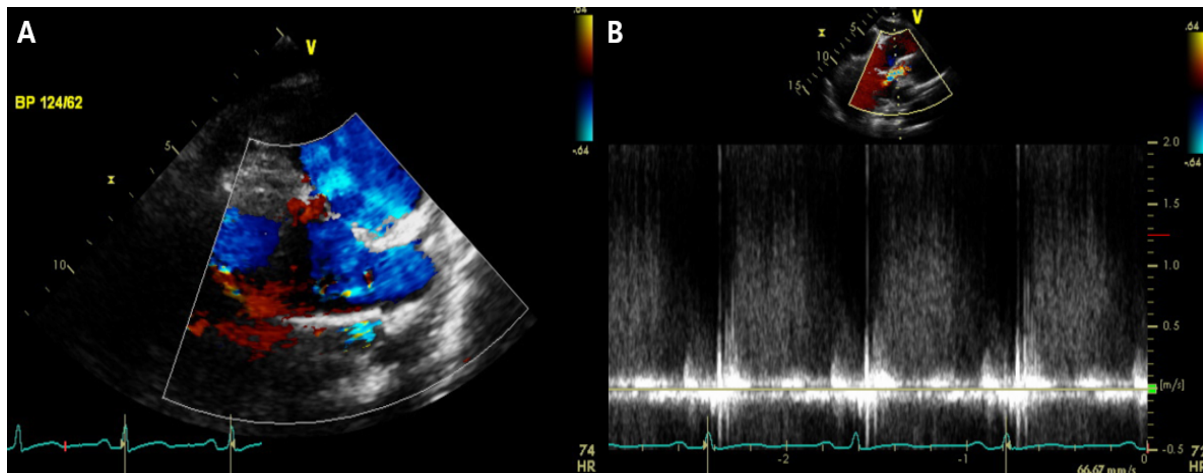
Transthoracic echocardiographic image showing a severe dilatation of the left main coronary artery (A) and a left-to-right shunt flow (B).
